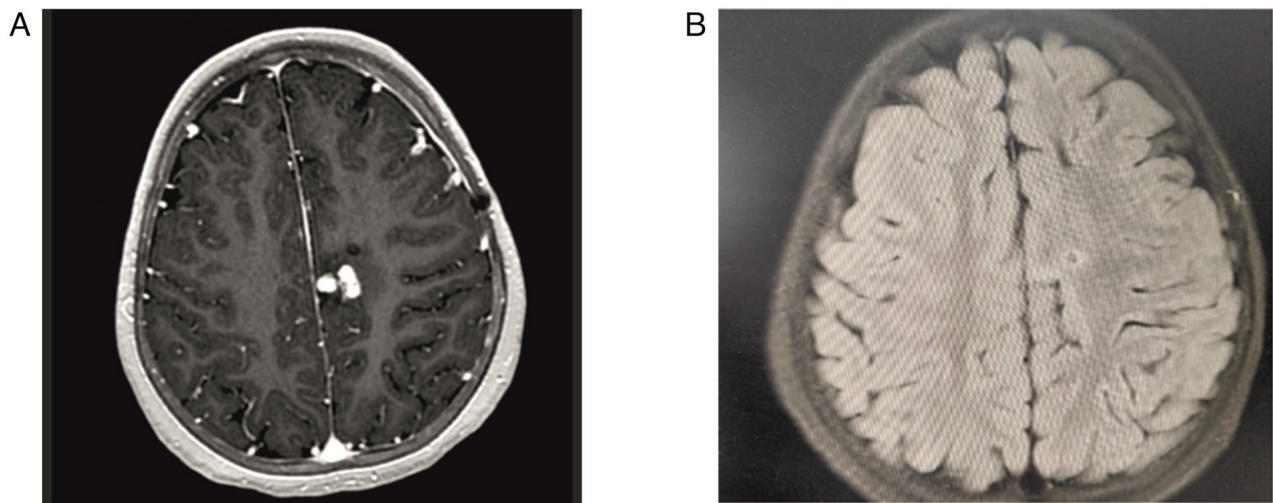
At the 5th and 12th months of non-classical anti-TB treatment, a millimetric lesion focus was observed in the left central semi-oval level on (A) magnetic resonance axial fluid-attenuated inversion recovery imaging, and no edema was observed. (B) In the magnetic resonance axial T1-weighted imaging, there were nodular areas of contrast medium uptake in the lesion area on the contrast medium-enhanced image, and a clearly regressed appearance was observed.
